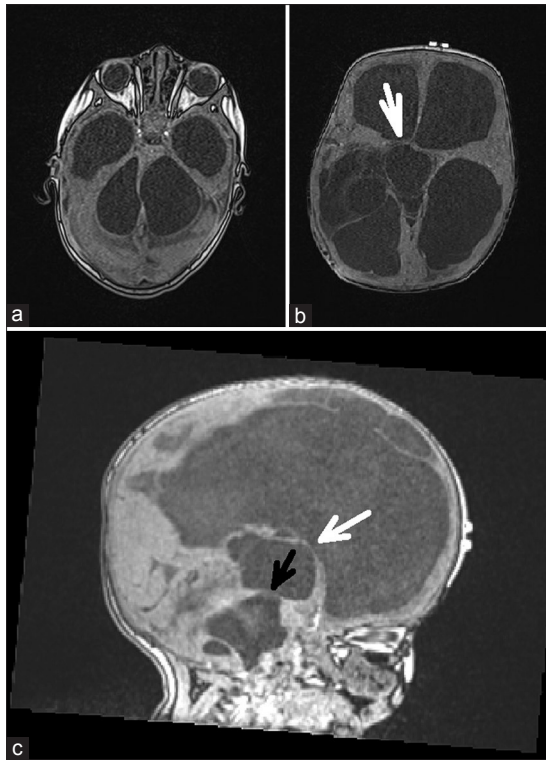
Case 1. Magnetic resonance imaging of the brain before surgery showed cysts of III and IV ventricles, several widening of the lateral ventricles. (a) The picture shows the septum divided the IV ventricle into two separate chambers. (b) The white arrow indicates the direction of the endoscope at perforating the anterior wall of the cyst of the III ventricle. (c) The black arrow points to the application site of connection with isolated IV ventricle
